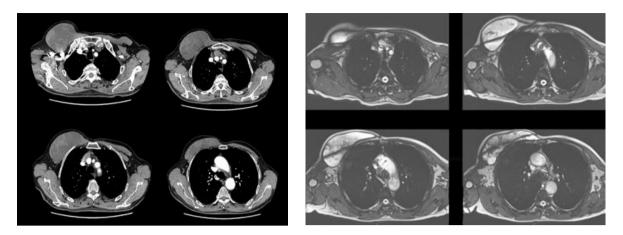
a. Mass image of the right hemithorax anterior chest wall in thorax CT. b. Mass image located in the anterior chest wall of the right hemithorax on thorax MR T2A images.
